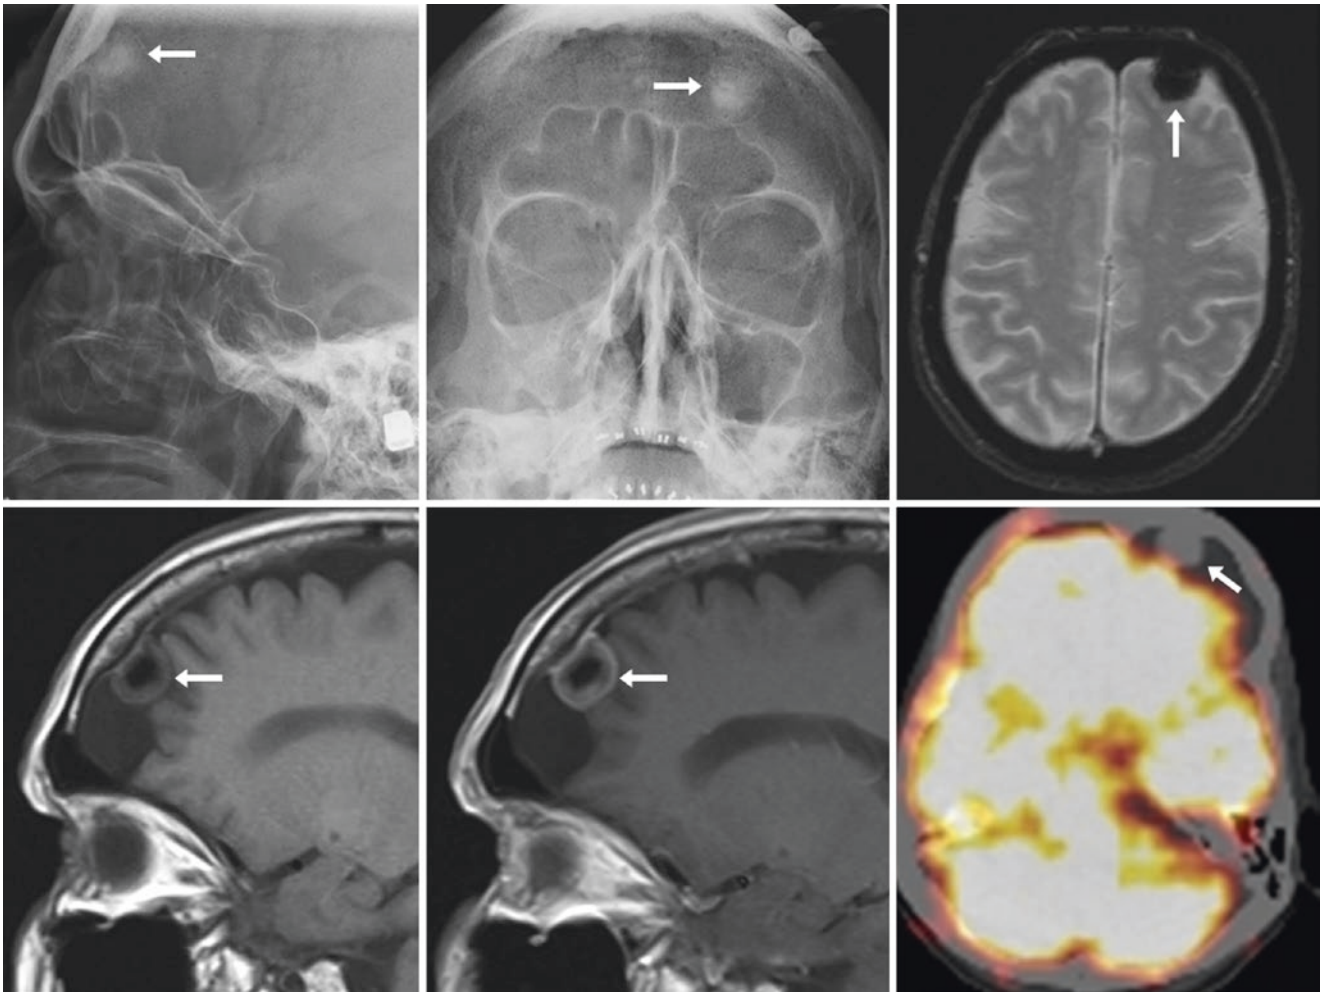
Comparison case of calcified meningioma. An 82 year old with a history of lung cancer had an extra-axial calcification (arrows) on lateral (top left) and anteroposterior (top middle) plain films. On MRI, there was dark signal on GE T2*WI (top right) and noncontrast
